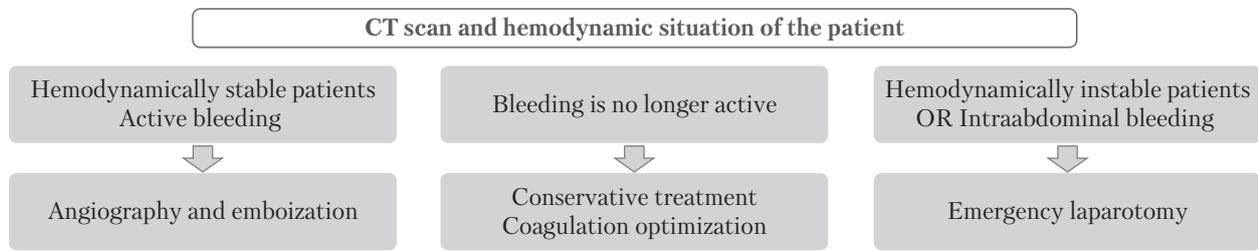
Proposed algorithm for management of perirectal hematomas and intra-abdominal bleeding (modified after [3] and [15]). The decision is made based on the contrast-enhanced CT scan and the patient's hemodynamic situation, similar to the algorithm used in pelvic trauma: in hemodynamically stable patients with active bleeding, angiography and embolization are performed; if the bleeding is no longer active, a conservative treatment with coagulation optimization is implemented. In cases of hemodynamically unstable patients or intra-abdominal bleeding, an emergency laparotomy is indicated
